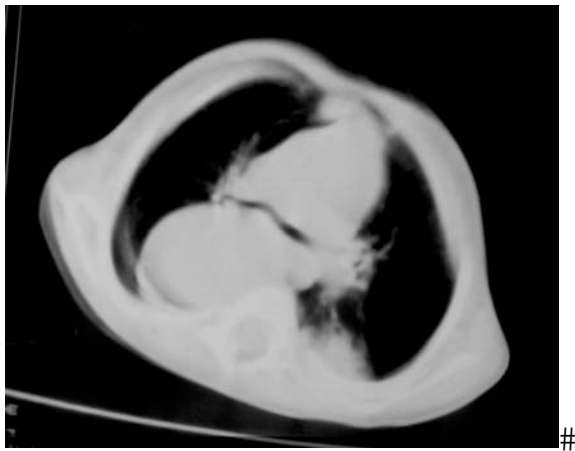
Computed tomography scan showing size and localization of the cystic mass
